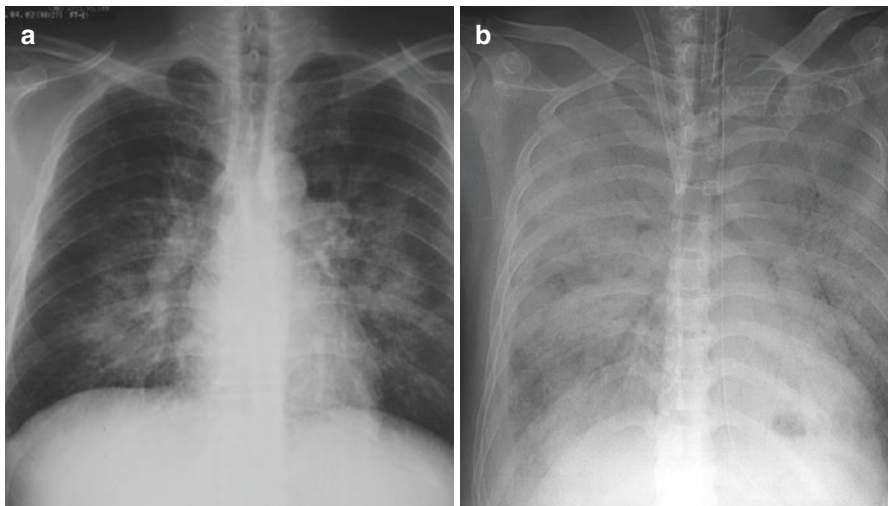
A case of atypical pneumonia caused by *Streptococcus pneumoniae*. A 55-year-old woman was administered infliximab every 3 months for 6 years for rheumatoid arthritis. On one occasion, she suffered from symptoms of common cold, including cough; this happened 3 days after taking the drug. After 7 days, she still had fever above 38°C and started to become short of breath. (a) Routine chest radiography on admission shows bilateral pneumonia shadows and pleural effusion on the right. (b) Computed tomography scan of the chest shows multiple bronchopneumonia shadows on both lungs
